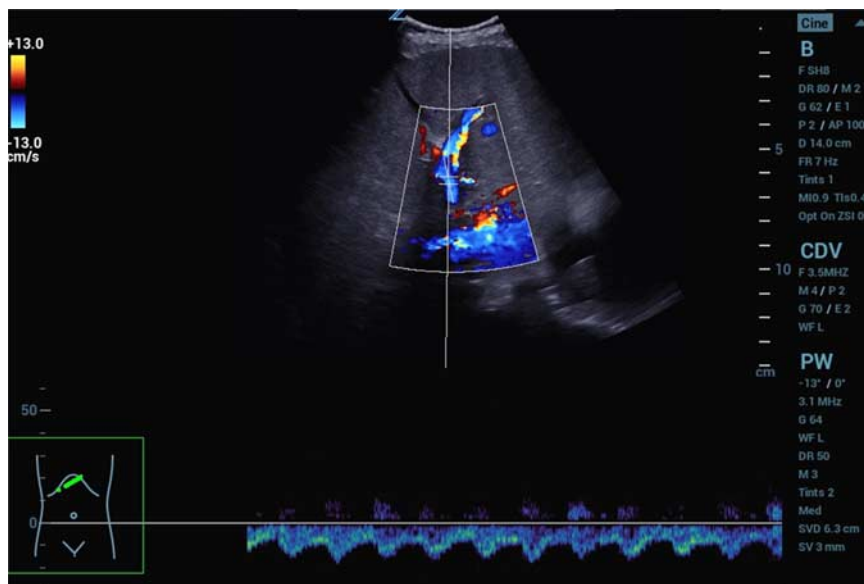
Ultrasound of reversal of portal vein flow in patient 2. Lateral intercostal view of the portal vein (C9-3 MHz, ZS3, Zonare Med Syst., Mountain View). Color Doppler revealed a red signal in the hepatic artery and a blue signal in the portal vein, corresponding to a reversal flow direction in the portal vein. The duplex curve showed negative values according to this finding.
